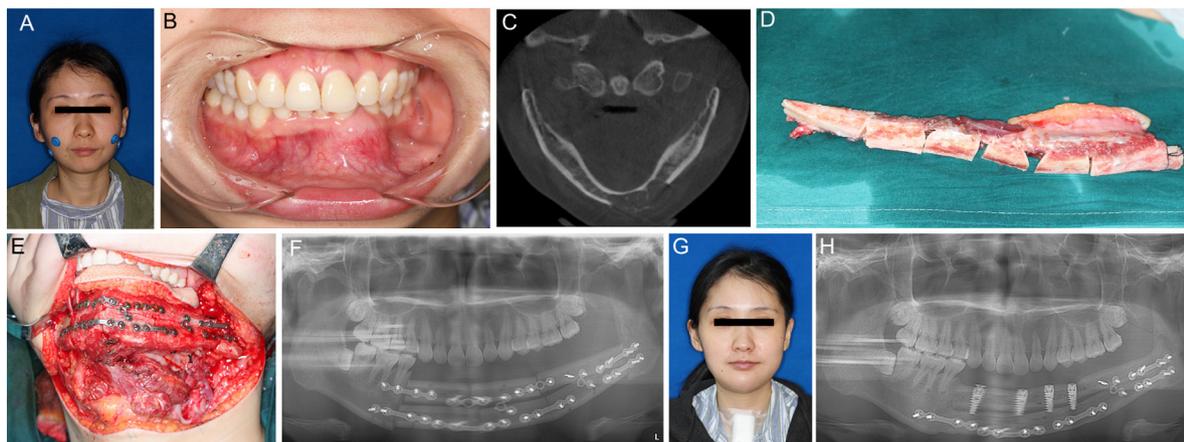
A 30-year-old female patient with ameloblastoma of the mandible. (A) Facial photograph before surgery; (B) oral photograph and (C) computed tomography image of ameloblastoma of the mandible; (D) fibula myocutaneous flap harvest and osteotomy; (E) double-barrel mandibular reconstruction with the fibula flap; (F) panoramic radiograph and (G) facial photograph showing an excellent postoperative appearance and sufficient height of the mandible; (H) panoramic radiograph showing dental implantation at 1 year post-surgery.
